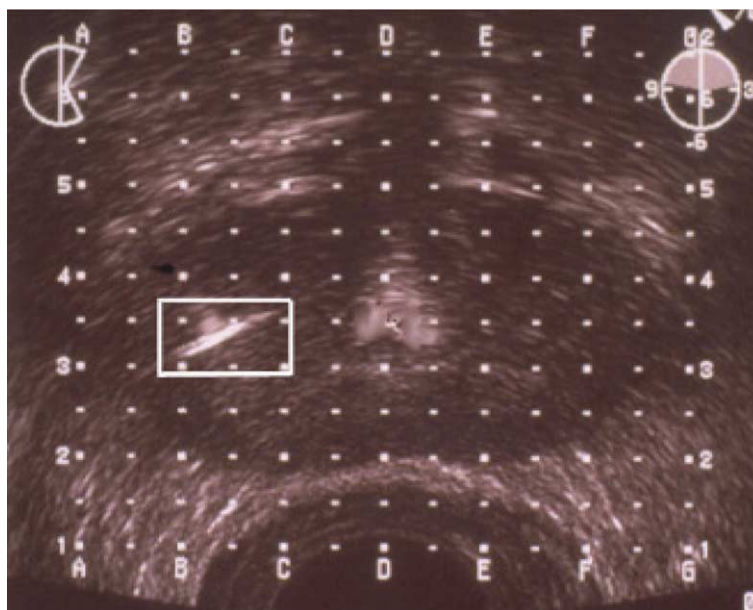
Placement of the seed under ultrasound guidance. The seed produces a dense hyperechoic signal on ultrasound. The overlying electronic template helps to define the seed placement.
